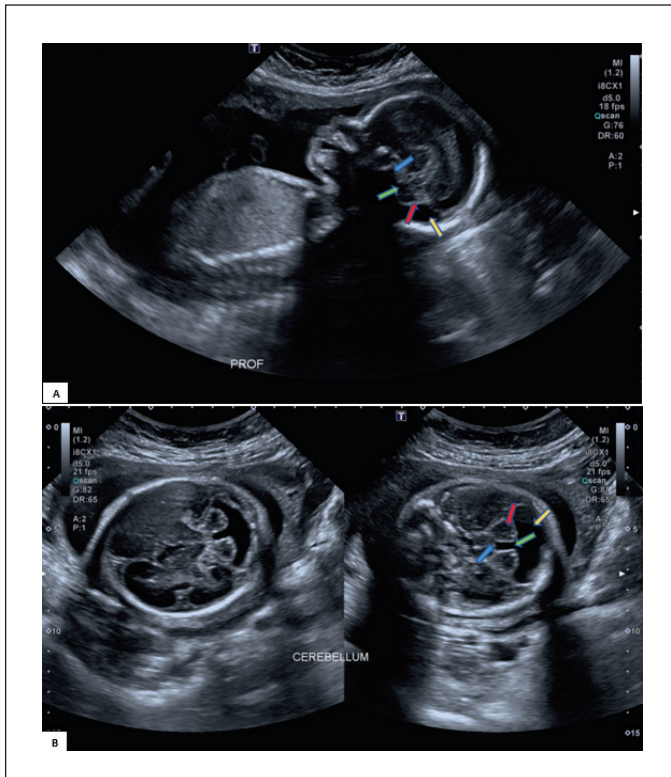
Obstetric 3rd-trimester ultrasound: (A) sagittal and (B) axial views presenting the posterior fossa cyst (yellow arrow) communicating with the fourth ventricle (blue arrow). The cerebellum is hypoplastic (pink arrow), and the cerebellar vermis is absent (green arrow).
